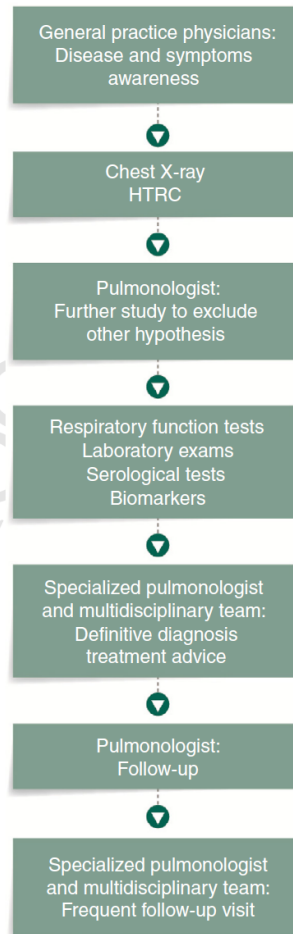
Idiopathic pulmonary fibrosis patient flow. HRCT: high-resolution computed tomography.
